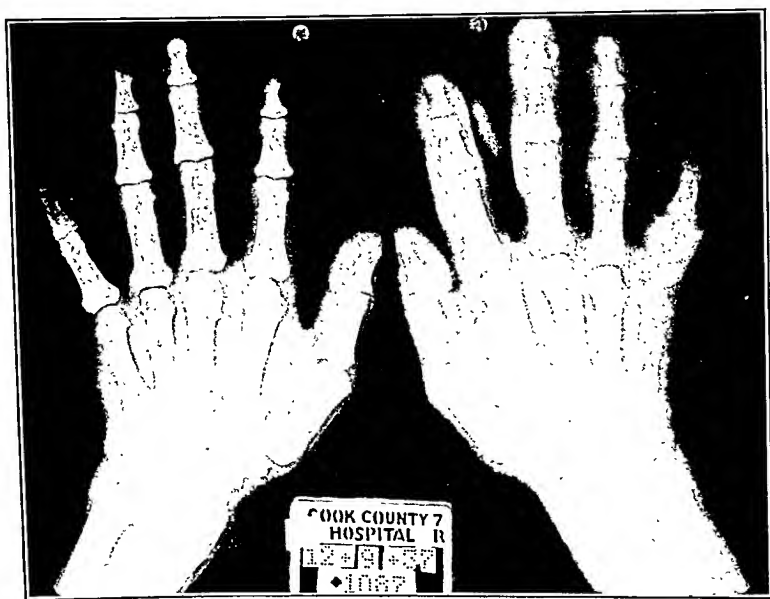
X-ray picture of both hands, showing the marked fibrocystic changes of the metacarpals and the phalanges, particularly the proximal phalanx of the right fifth finger and also the right ulna. This picture was taken about six weeks after surgery was done.
